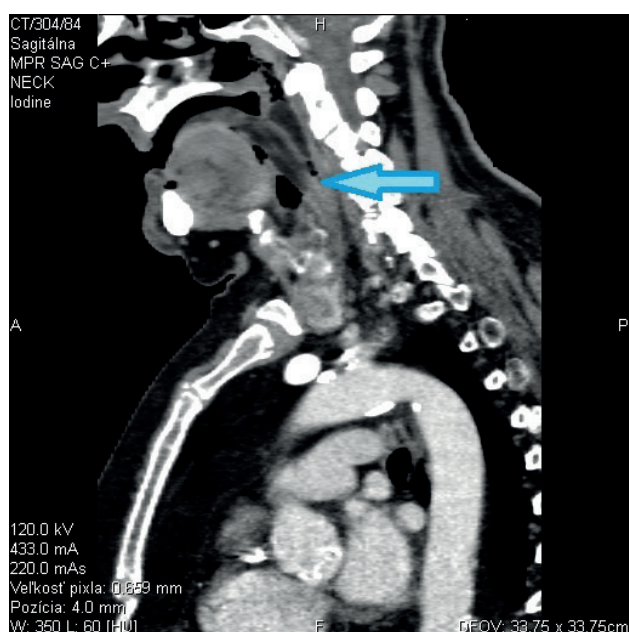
Sagittal CT scan of the tumor (marked by arrow).
